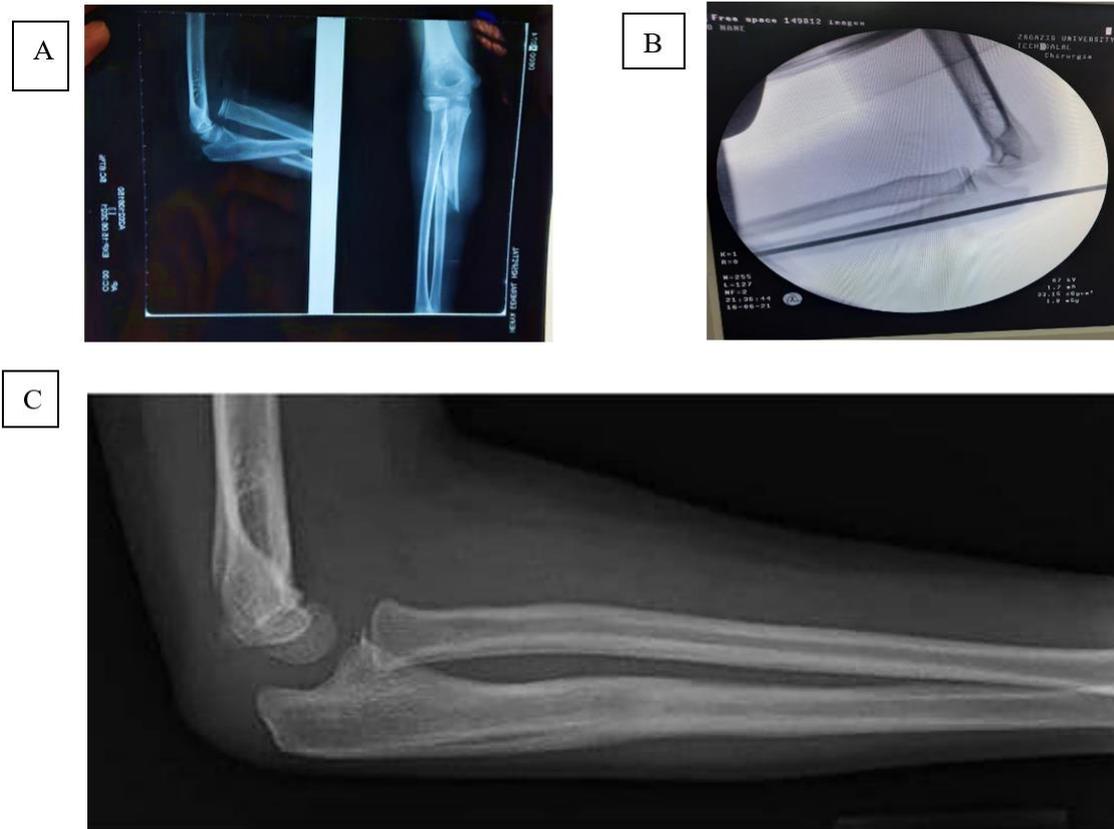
( A) Male patient 9 years old presented with a history of falling from the swing, Bado type 1, and the operation was done the same day of admission, gentle traction was applied on the forearm and gentle pushing of the head of the radius applied and anatomical reduction obtained k wire inserted, the patient follow up for six (6) months and final result according to Stewart handy, VAS and DASH scoring system was excellent. The boy =, sustaining a Bado type-I Monteggia injury (B) Intraoperative CMR and wiring, (C) Check x-ray.
